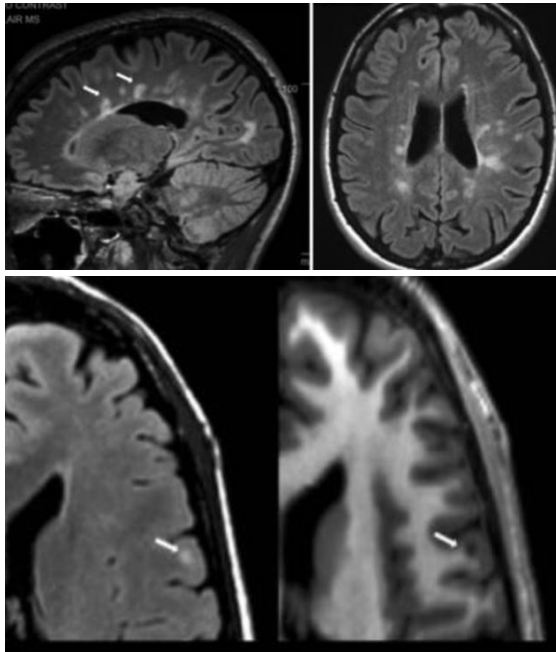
MRI image of the brain of a patient with multiple sclerosis. There are perivenular lesions, known as 'Dawson's fingers' (arrow), and several periventricular lesions with a dominant ovoid/oval configuration (Hemond & Bakshi, 2018).
